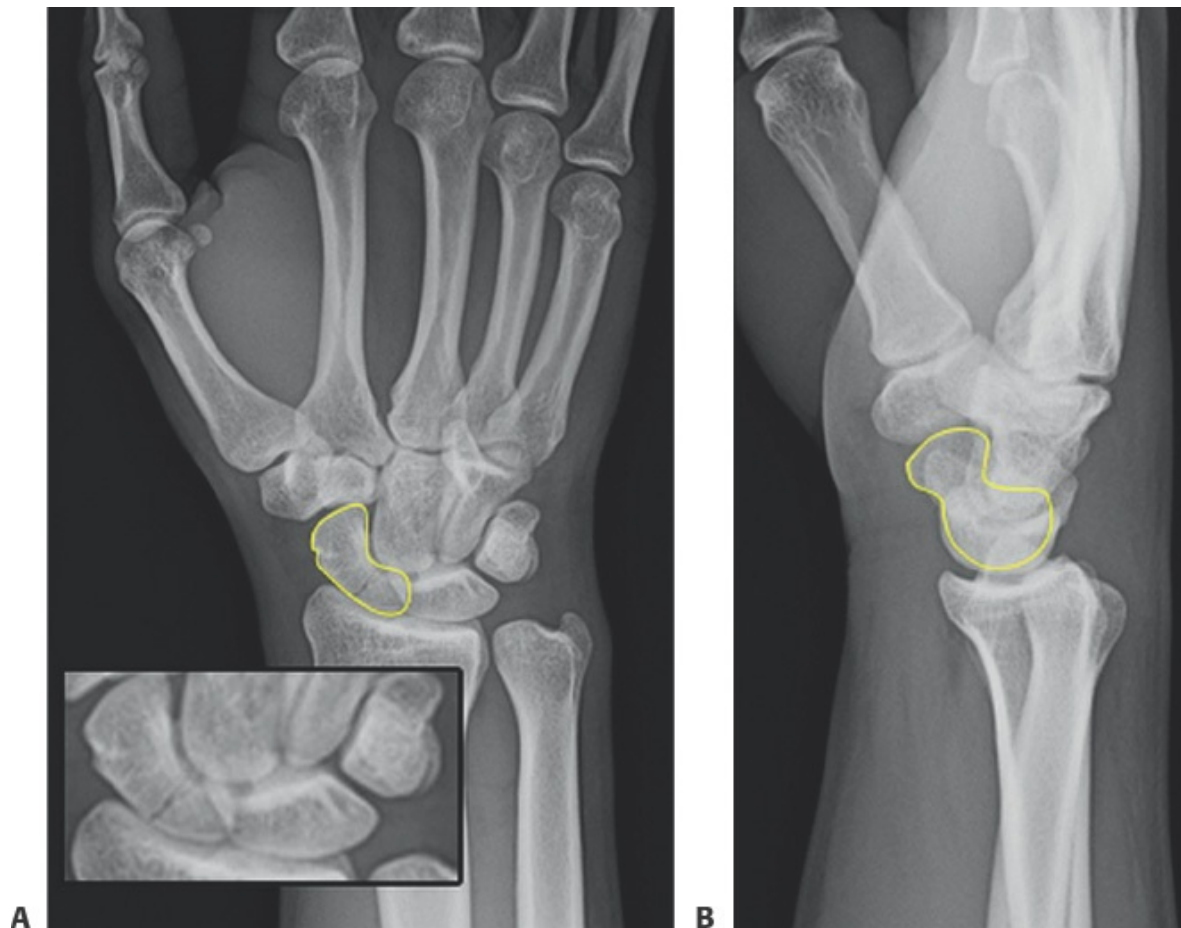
• A. PA (B) and lateral radiographs showing nondisplaced fracture of the scaphoid waist (scaphoid
